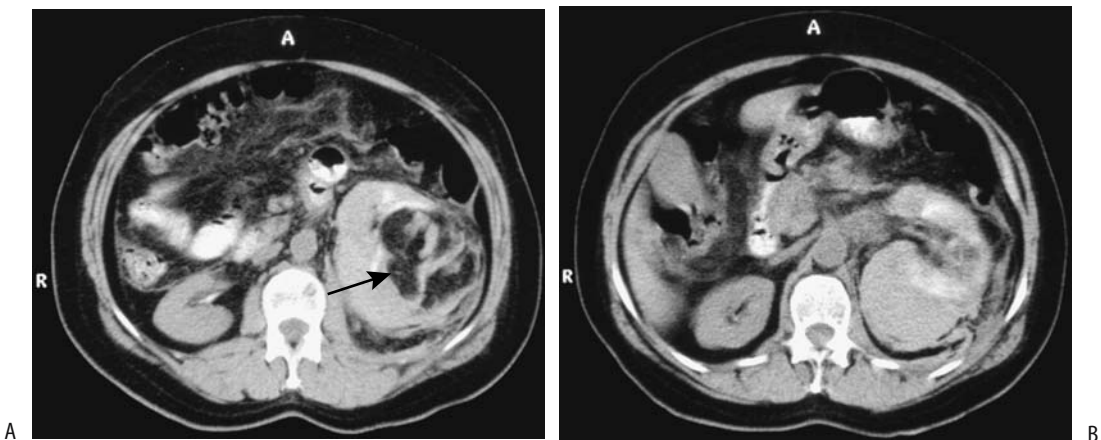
Bleeding left renal angiomyolipoma. Noncontrast CT reveals a fat-containing left renal tumor (A, arrow), surrounded by a well-margined infiltrate having a CT density similar to aorta (B). (Courtesy of Algirdas Basevicius, M.D., Kaunas Medical University, Kaunas, Lithuania.)
